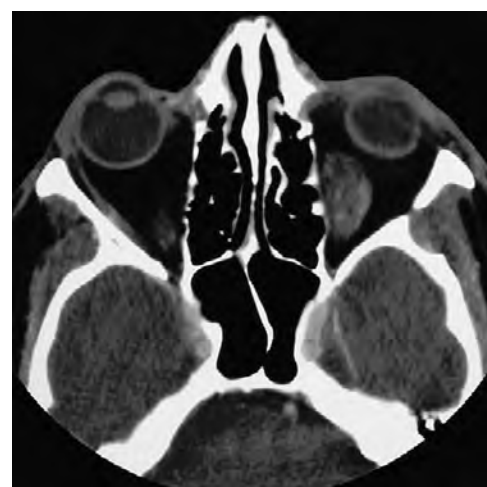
Contrast-enhanced computed tomography scan of a patient with a right-sided orbital pseudotumor.
